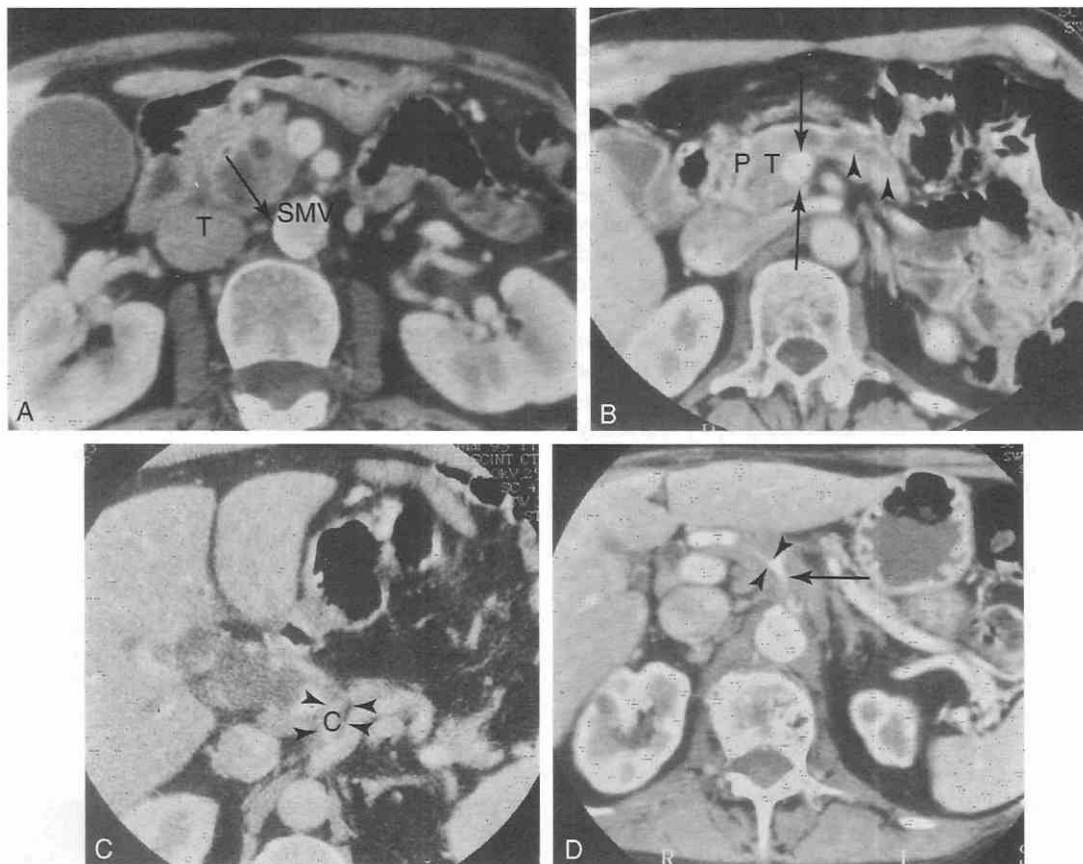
A, CT scan of a 67-year-old woman with grade 1 vessel involvement. Pancreatic-phase thin-section CT image of pancreatic head adenocarcinoma (T) shows minimal tumor contiguity to the superior mesenteric vein (SMV) (arrow). Contiguity is less than one quarter the circumference of the vessel. At surgery, the SMV was found to be free of tumor.
